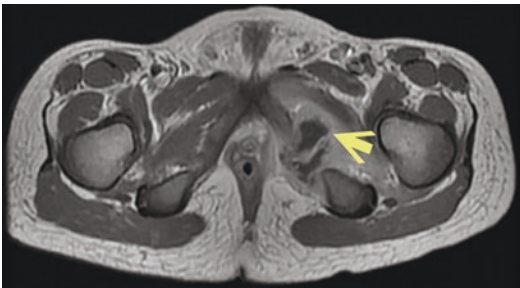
Magnetic resonance imaging showed a rim-enhancing lesion near the left femoral adductors (arrow), about 2.7 cm in diameter
